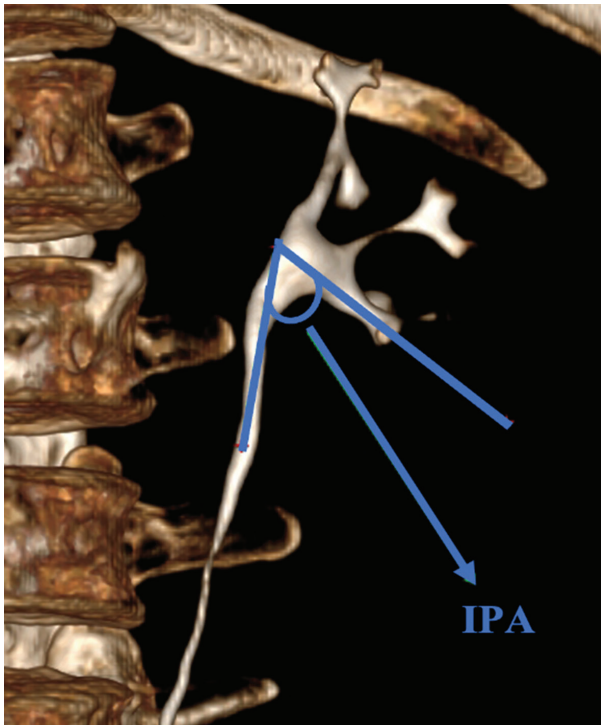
3D Volume Rendered CT urography Image showing measurement of Infundibulopelvic angle (IPA) using Elbahnasy method.
